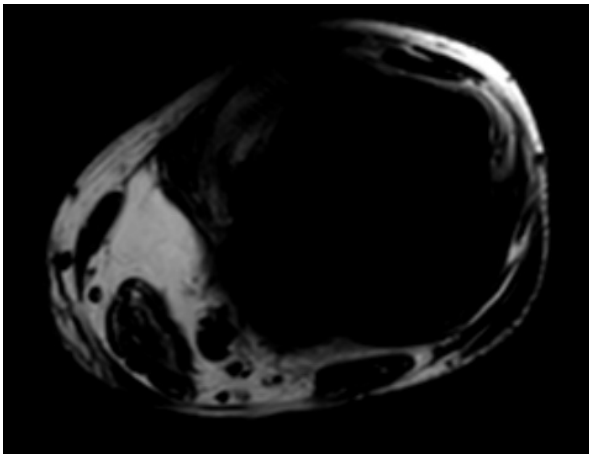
MRI-T1W axial image
